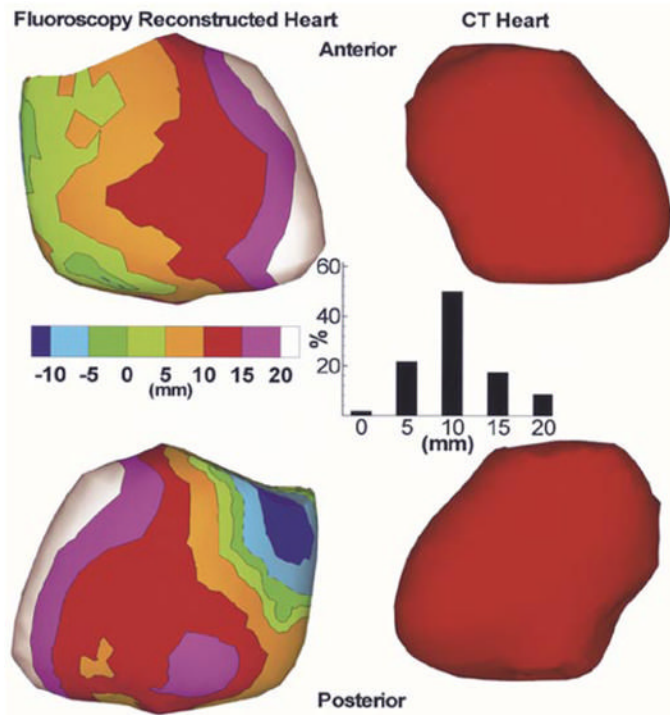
Left: Signed distance error maps for anterior (top) and posterior (bottom) views of a fluoroscopy reconstructed envelope in a human subject. The CT heart (right) is shown for reference. Inset shows the histogram of nodes on the fluoroscopy reconstructed envelope versus absolute distance (0, 5, 10, 15, and 20 mm) from the CT heart.
